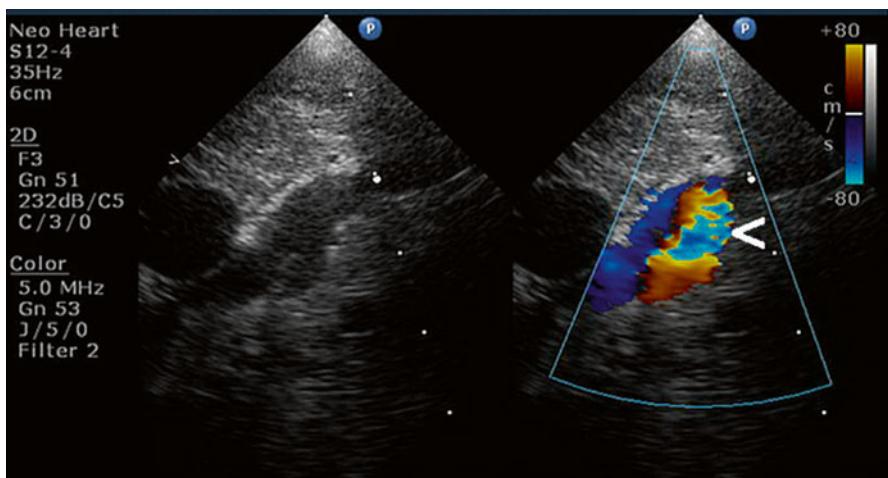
Echocardiogram image showing the ascending vessel (*white arrow*) connecting to the left superior vena cava
